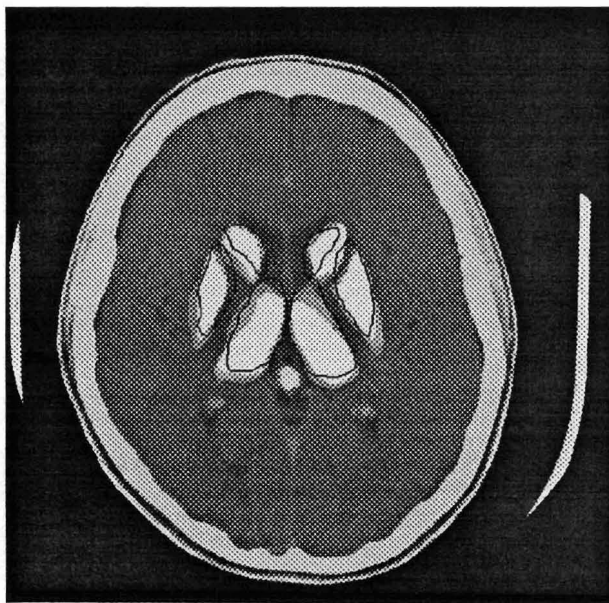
Comparing typical computer with the experts. The computer-generated outlines are superimposed on the corresponding CT slice, along with the union of ROI's defined by the experts.
